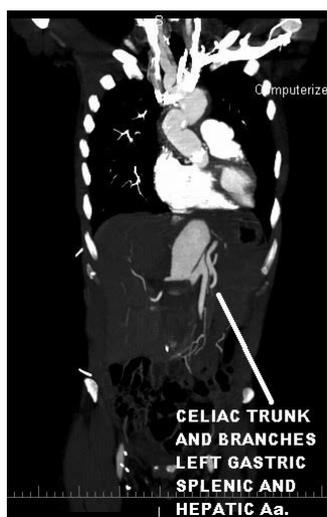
Computed tomography angiography scan of the origin and distribution of the celiac trunk from the dissecting abdominal aorta.
